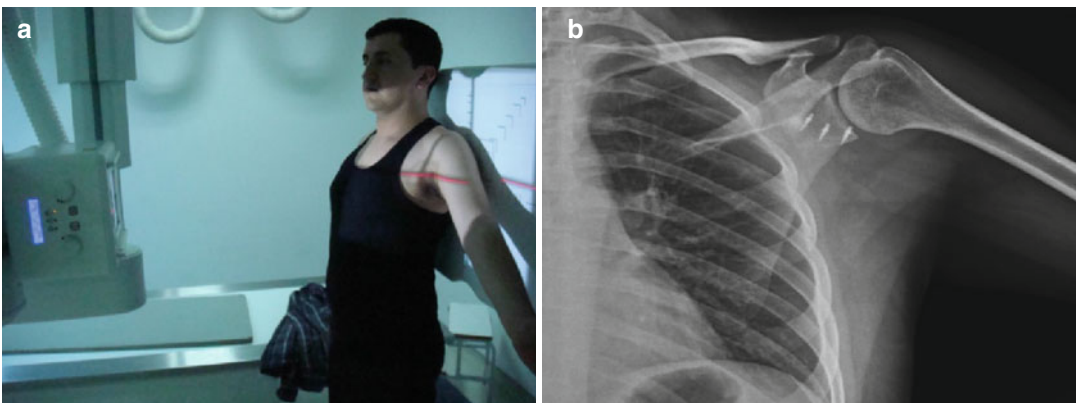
(a) Position of the patient and x-ray during the Grashey radiography. (b) Image of Grashey radiography
